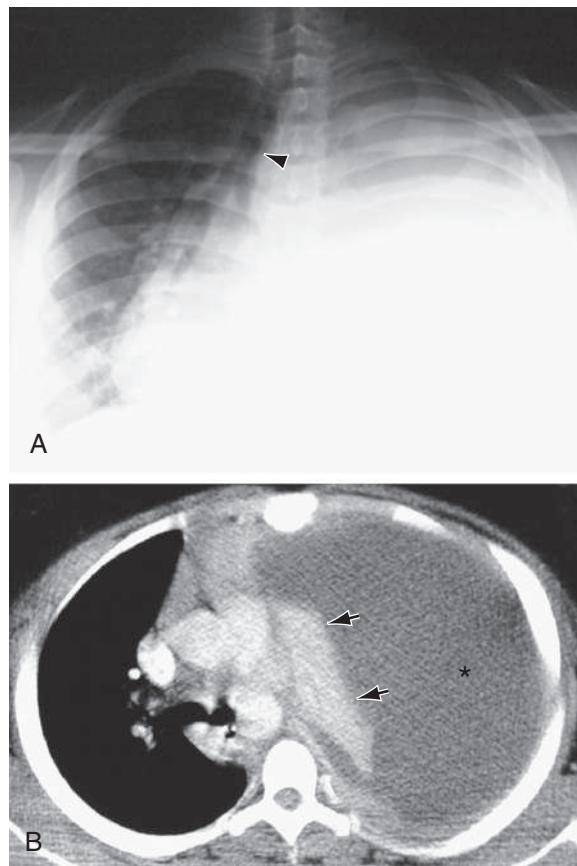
Empyema and pneumonia in a teenager. A, Chest radiograph shows opacification of the left thorax. Note shift of mediastinum and trachea (arrowhead) to the right. B, Thoracic CT scan shows massive left pleural effusion (asterisk). Note the compression and atelectasis of the left lung (arrows) and shift of the mediastinum to the right.
